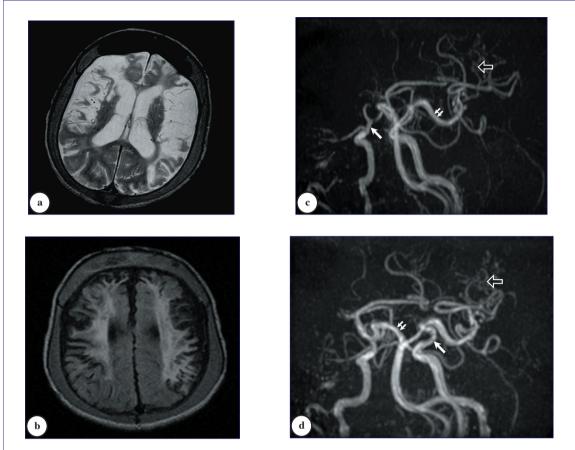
a) Axial T2-weighted brain MR image and b) Axial fluid-attenuated inversion recovery (FLAIR) image showing right frontal and left frontoparietal cystic encephalomalacia and gliosis due to old infarction, as well as thick diploic space. c & d) MR angiography showing severely attenuated caliber and occlusion of the distal part of both internal carotid arteries (arrow) with normal caliber of both posterior cerebral arteries (double small arrows) and dilated collaterals (open arrow).
